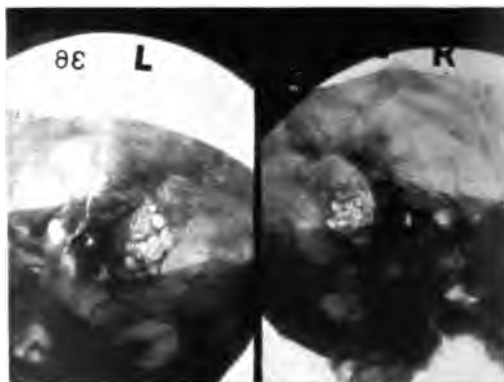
CASE NO. 8268. GIRL AGE 13. SAME TYPE AS ROENTGENOGRAM FIG. 10.
